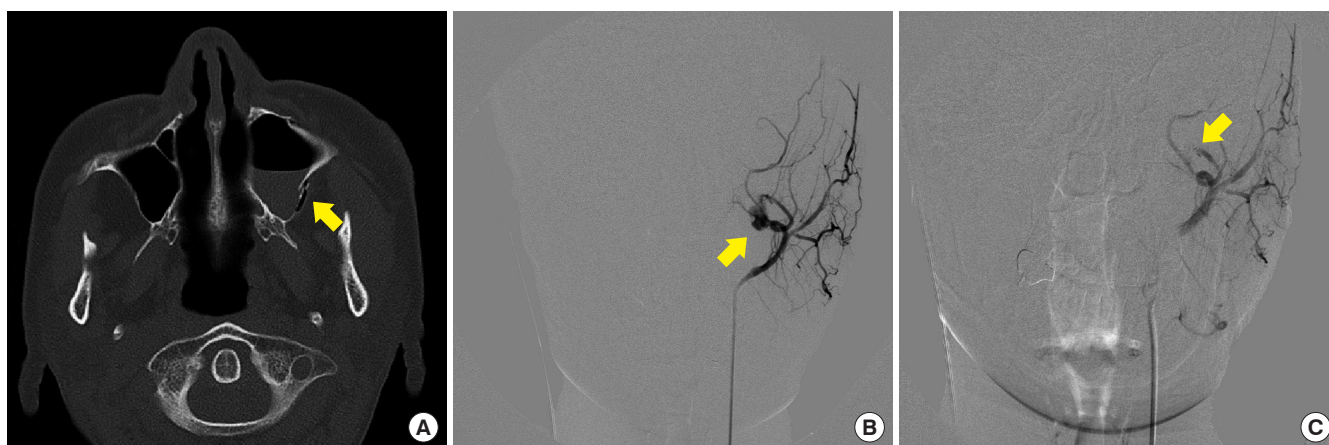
(A) Preoperative computed tomography scan of the facial bone in a 46-year-old female (patient 1) presenting with left zygomaticomaxillary complex fracture (arrow) following blunt trauma. (B) Angiography of patient 1 revealing huge pseudoaneurysm of left sphenopalatine artery (arrow). (C) Angiography of patient 1 after endovascular embolization of internal maxillary artery with gelatin sponge and coil (arrow). Embolization was successfully done without any recurrent bleeding after the procedure.
